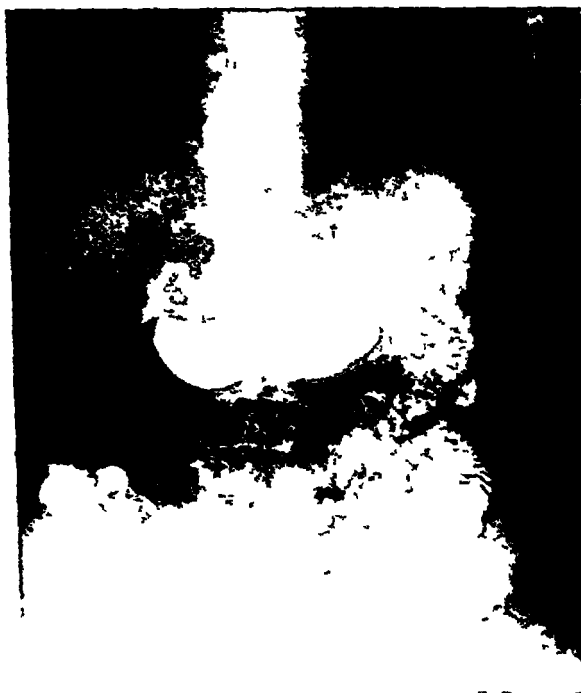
Case I Roentgenogram taken six hours after the ingestion of a Rieder meal before administration of atropin
